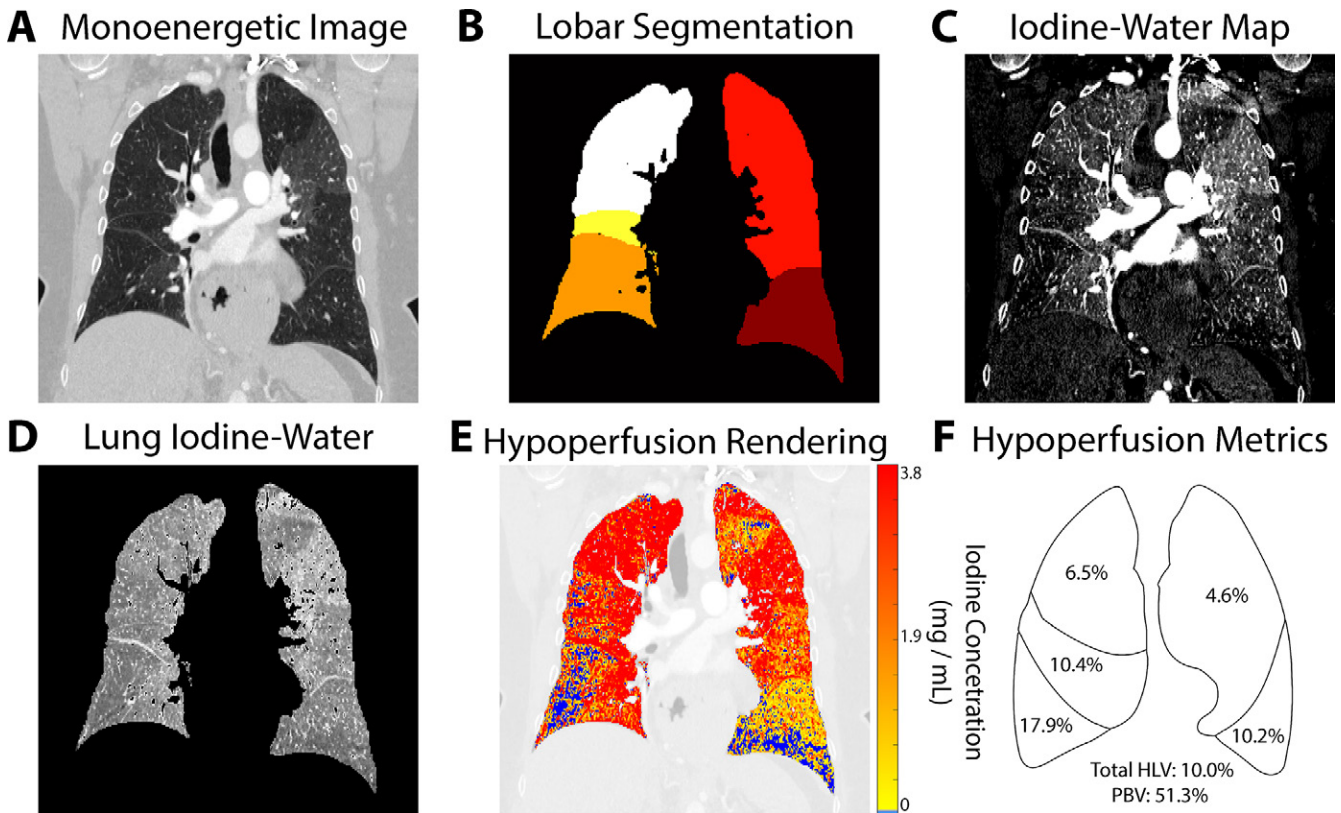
Automated segmentation and quantification of hypoperfused lung volume. CT angiograms generated (A) virtual monoenergetic images, which were (B) automatically segmented to identify lobar boundaries and remove other thoracic anatomy. These lobar segmentations were applied to (C) iodine-water images to (D) isolate the lung parenchyma. (E, F) Fused maps were then used to visualize (E) hypoperfused pixels, shown in blue, and quantify the percentage of hypoperfused pixels in each lobe (F). A patient with chronic thromboembolic pulmonary hypertension with areas of hypoperfusion primarily in both lower lobes is shown as an example. HLV = hypoperfused lung volume, PBV = pulmonary blood volume.
